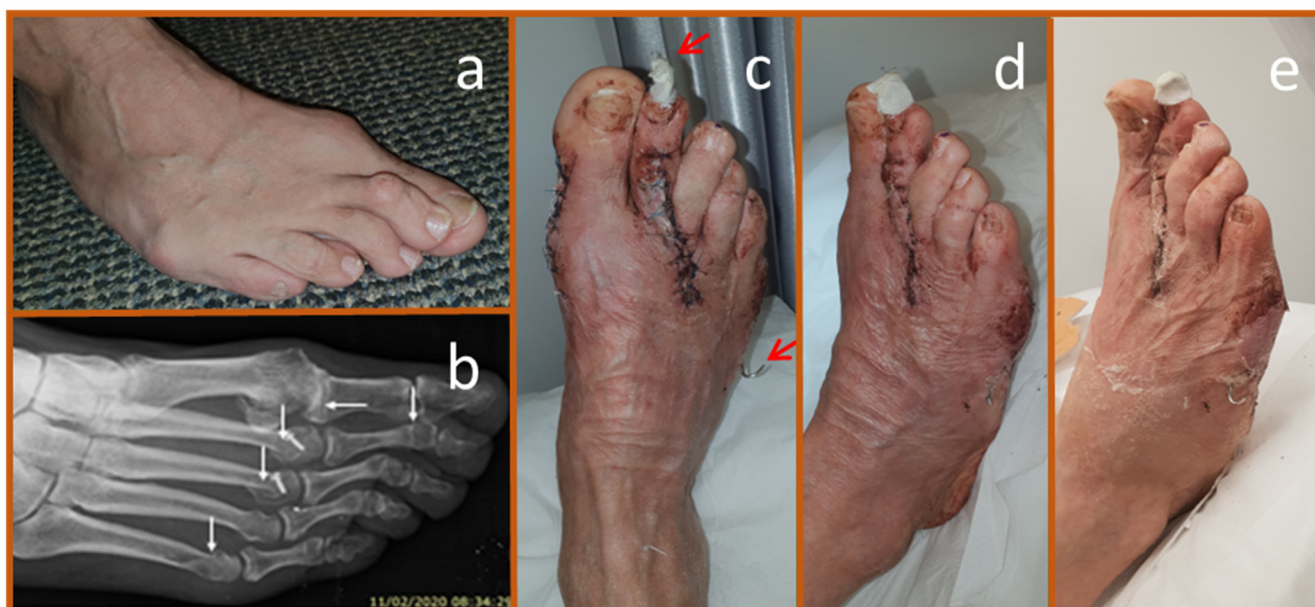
Reduction of Swelling Following Forefoot Surgeries and Osteotomies. (a). Preoperative forefoot deformities, including hallux valgus, hammer toe of the second digit, subluxation of the 2nd and 3rd metatarsophalangeal joints, and a Bunionette deformity. (b). X-ray taken two months post-surgery showing osteotomy of the proximal phalanx base of the big toe, Weil osteotomies of the 2nd and 3rd metatarsals, Chevron osteotomy of the 5th metatarsal, and PIPJ arthrodesis of the 2nd hammer toe (arrows). (c). Clinical image at the first dressing change, three weeks after surgery (copper dressings were applied intraoperatively), showing well-healing surgical wounds without signs of inflammation. The absence of swelling and the presence of skin wrinkles are notable. The tips of the K-wires stabilizing the 2nd toe and 5th metatarsal are visible (marked with red arrows); the second toe K-wire is wrapped in plaster to prevent accidental pullout. (d). Oblique view of the same foot at the same visit, after suture removal, clearly demonstrating reduced swelling. (e). Clinical images at five weeks post-surgery showing maintained skin wrinkles and continued absence of swelling.
